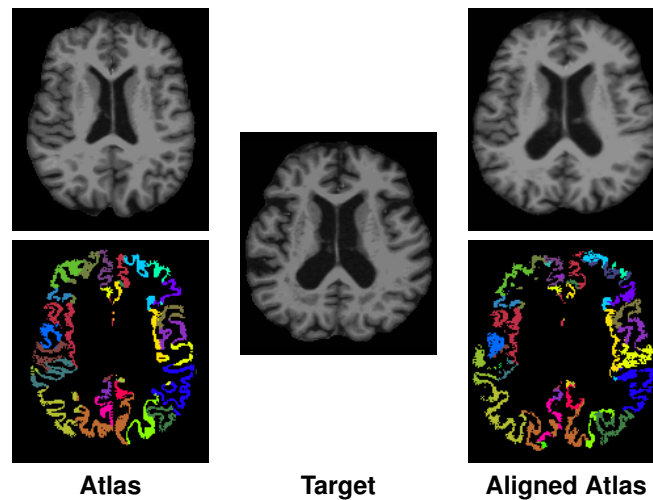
Shown is an example of an atlas alignment using image registration between two different brain magnetic resonance images. The atlas image (top left) is transformed (top right) to be aligned with the target image (center). The transformation allows the anatomical labels from the atlas (bottom left) to be directly transferred (bottom right) to label the target image.
